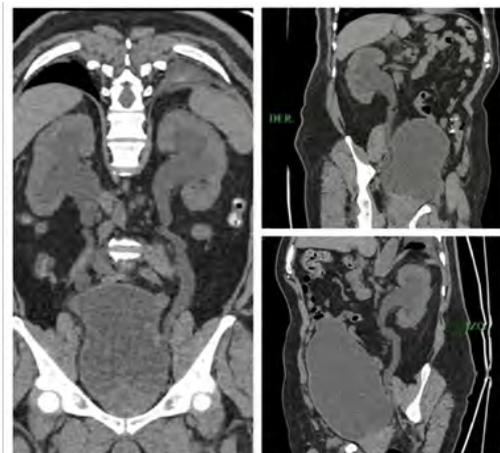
Simple CT with grade IV hydronephrosis showing right kidney with measurements of 13.4 x 7.8 x 6.4 cm with increased dimensions and cortical thinning caused by the presence of hydronephrosis. Left kidney with measures of 12.3 x 7.1 x 5 cm with increased dimensions and cortical thinning caused by the presence of hydronephrosis.
